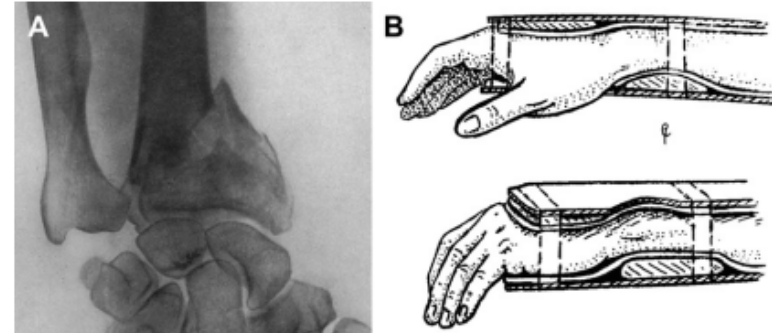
X-rays allowed physicians at the turn of the twentieth century to better diagnose distal radius fractures, but treatment options were still limited. Even comminuted fractures (A) were treated with splinting (B). (Reprinted from Cotton FJ. The pathology of fracture of the lower extremity of the radius. Ann Surg 1900;32:194-218; and Cotton F. Dislocations and joint fractures. Philadelphia: W.B. Saunders; 1910.)
